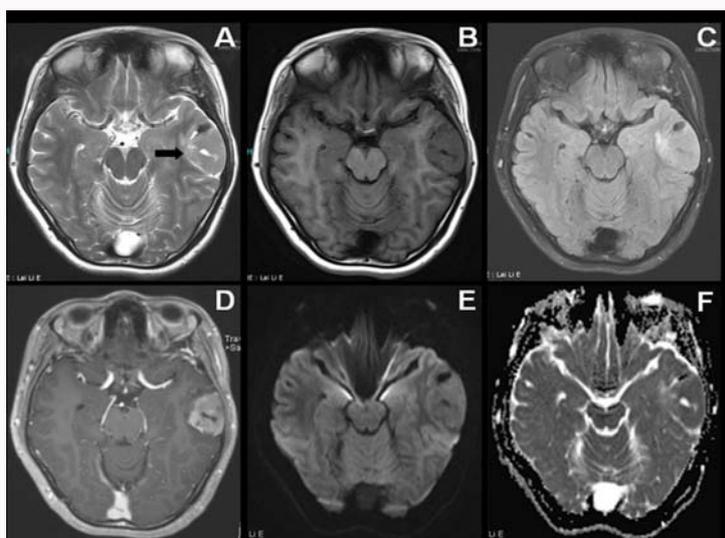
Female, 21 years-old, admitted to the hospital after sudden limb twitching for 2 weeks. Solid pattern of Pleomorphic Xanthoastrocytoma (PXA). MRI shows a solid mass in the subcortical area of the left temporal lobe. (A) Unenhanced axial T2-weighted image of an isointense, slightly hyperintense lesion. (B) Unenhanced axial T1-weighted image of a hypointense lesion. (C) Axial FLAIR-weighted image of a slightly hyperintense lesion. (D) Moderate contrast enhancement of solid components on enhanced T1-weighted imaging. (E) Diffusion-Weighted Imaging (DWI) of the mass showing cystic hypointense and solid slightly hyperintense regions. (F) Apparent Diffusion Coefficient (ADC) of the cystic hyper-intense lesion.
